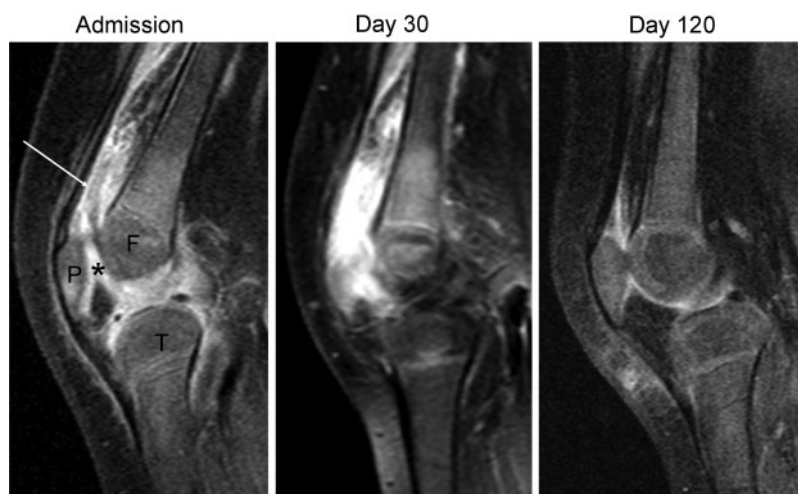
Sagittal MRI (T1 TSE) of the left knee over time. At baseline, increased contrast uptake of the synovium (asterisk) as well as the bursae (arrow) is seen; during follow-up after an initial increase in disease activity, significant reduction of pathological enhancement at the final control is observed. P, Patella; F, femur; T, tibia.
